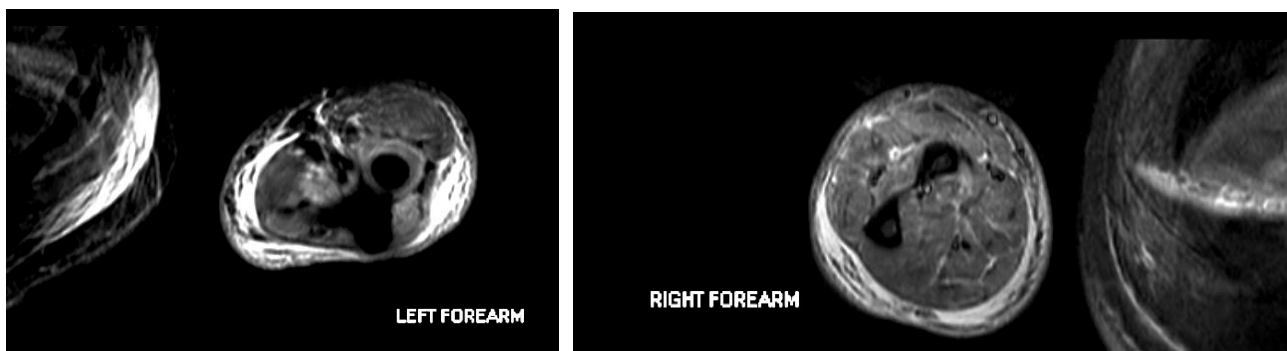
MRI scan of the forearms demonstrating generalized high signal within the muscle consistent with myositis and a moderate amount of edema within the subcutaneous fat.
